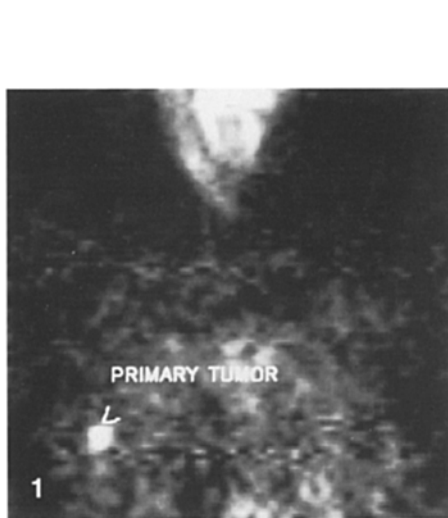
Anterior ^{18}F -FDG PET images showing uptake in the primary tumor of the right breast and no uptake in the axilla
